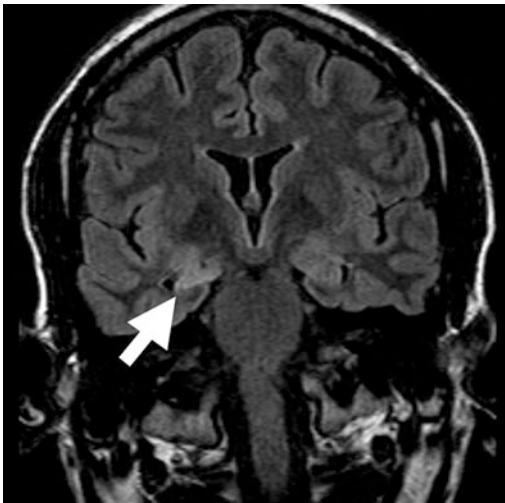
High-resolution MRI detects mesial temporal sclerosis (MTS) in 80–90% of cases
